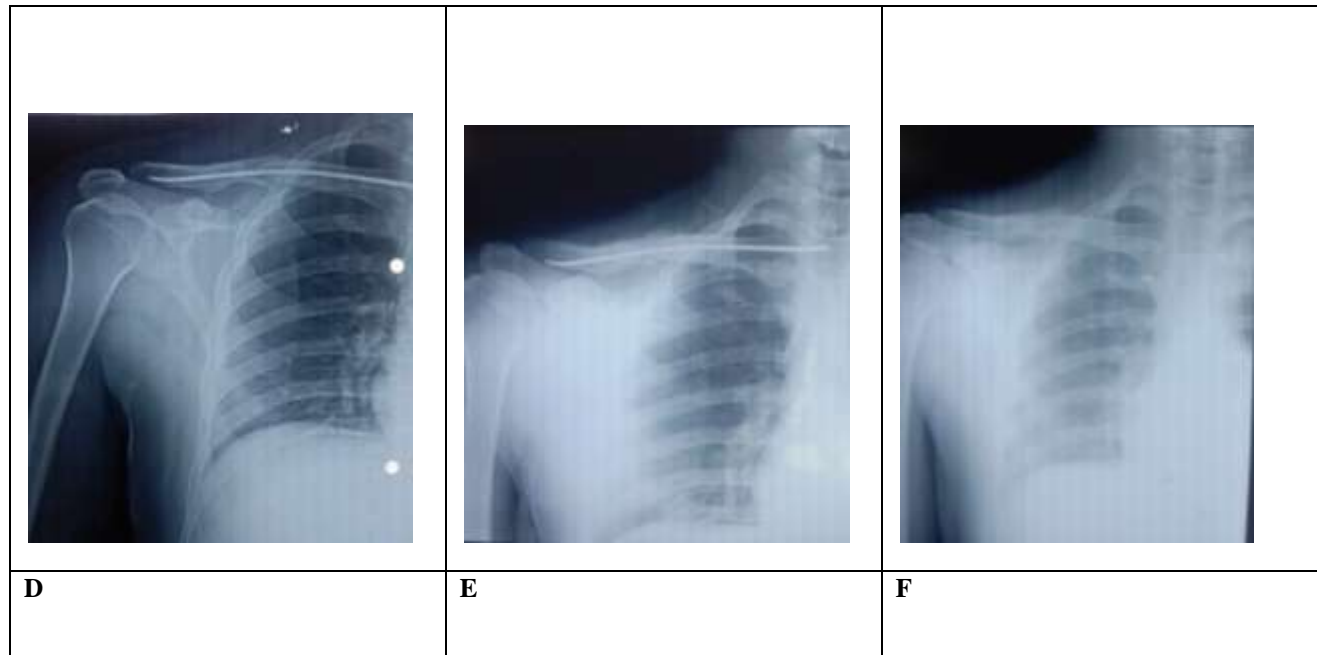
Radiographs A- Pre op X-ray, B-Immediate post op x-ray fracture fixed with 2.5 mm TENS , C-1 month follow up X- ray , D- 3 months follow up X- ray ,E-4 months follow up X- ray showing medial nail migration, F- After Implant removal.
